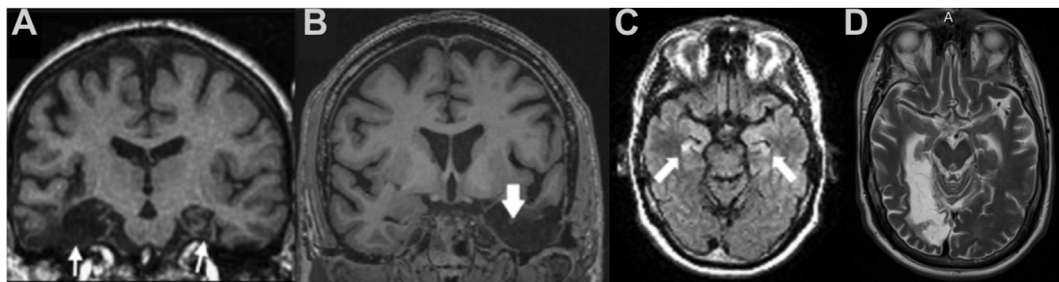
Representative structural MRI scans of the four amnesic cases (A: D.A.; B: L.D.; C: S.P.; D: M.H.).
